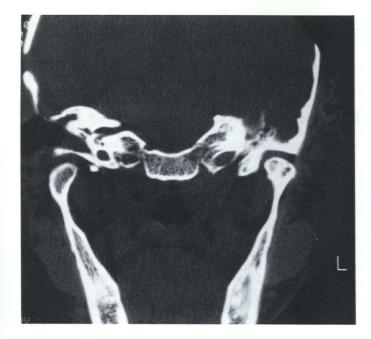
Post HBO therapy: high-resolution CT after extended radical mastoidectomy, split-thickness skin graft of the temporal bone defect, ten of 20 HBO treatments, and oral ciprofloxacin. Less bone irregularity of anterior external auditory canal wall.
